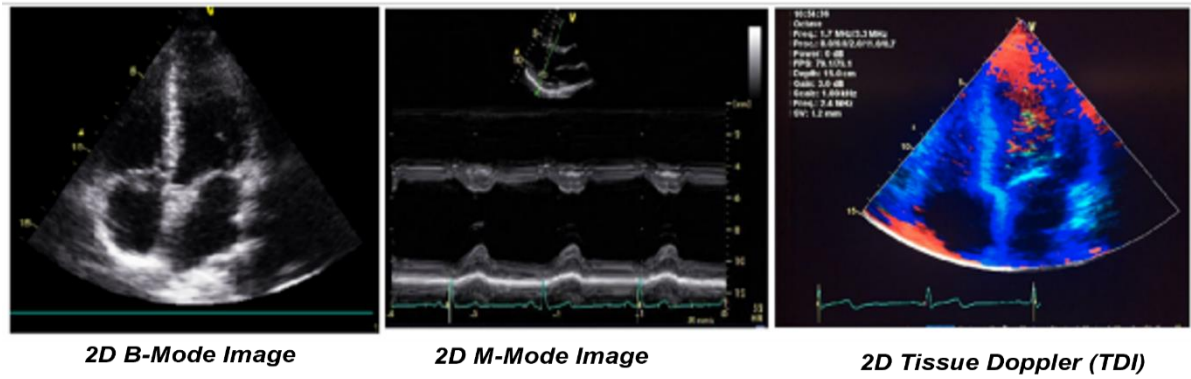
Examples of different modalities used in transthoracic echocardiography, showing B-Mode, M-Mode, and TDI echocardiograms.
